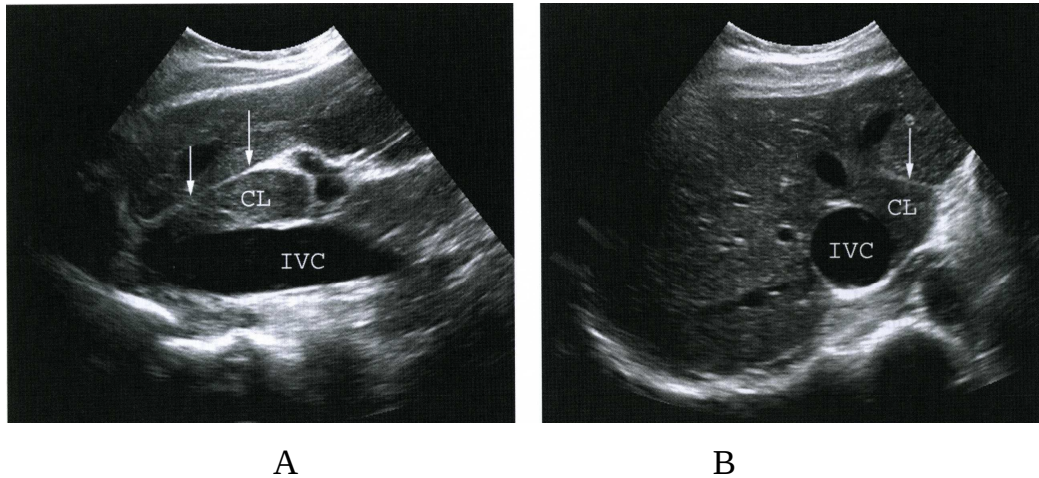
A Longitudinal B Axial ultrasound image of the caudate lobe (Rumak et, al2005) (CL=caudate lobe, IVC=inferior vena cava)
